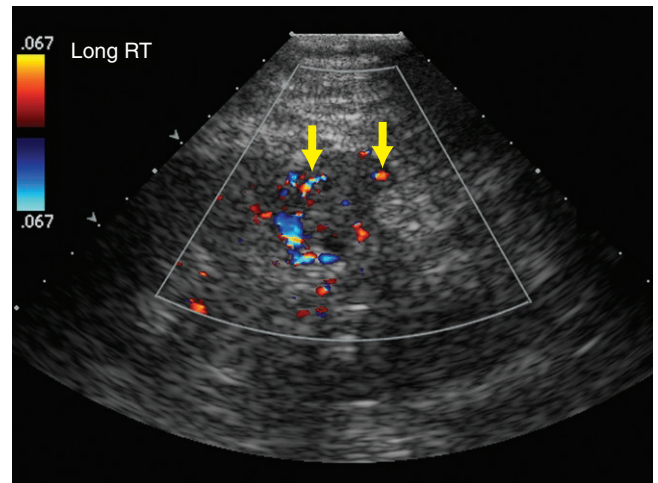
Color Doppler ultrasound demonstrates the mass with color flow (arrows) in the mass. Biopsy was performed to demonstrate a low-grade clear cell carcinoma.
